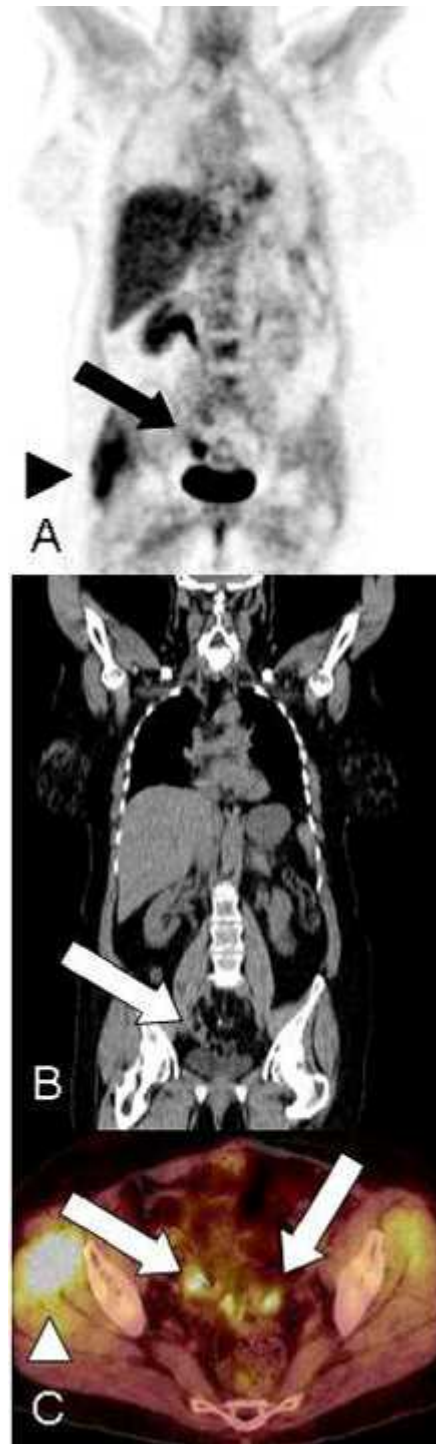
Coronal PET, intravenous contrast enhanced CT, and fused axial PET/CT images in a 59-year-old woman with recurrent ovarian cancer in the pelvis previously treated with hysterectomy and bilateral salpingo-oophorectomy with a CA-125 level of 11,500. A, There is a discrete focus of avid FDG uptake in the pelvis on PET (arrows). Based on the PET images alone it is difficult to accurately differentiate this uptake from normal bowel uptake, ureter or a bladder diverticulum. Incidental note is made of increased FDG uptake in the upper right thigh (arrowhead). B, There is a soft tissue lesion in the pelvis on CT (arrow). C, Fused images confirms increased FDG uptake in two soft tissue pelvic lesions rather than in bowel and therefore these deposits are likely metastases (arrows). Upper right thigh FDG uptake is again noted (arrowhead) without a mass on CT. This increased FDG uptake is due to muscle activity and not metastatic disease.
